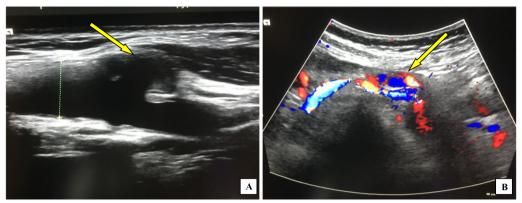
Duplex ultrasonography (USG) of CAs: saccular aneurysm (yellow arrows) of common carotid artery (CCA) bifurcation (A, B)
